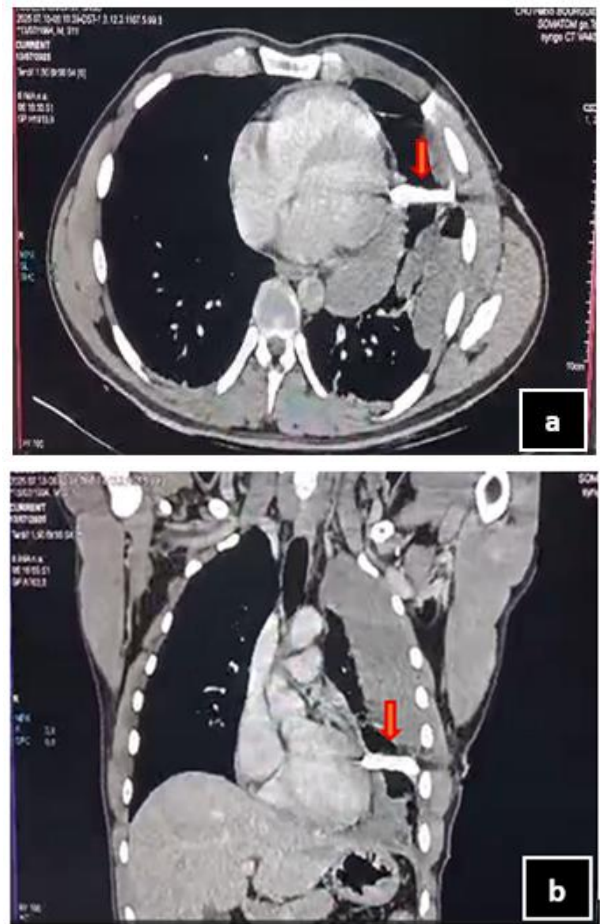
Transverse (a) and coronal (b) CT scans showing a 4 cm glass fragment lodged in the angula, in close contact with the right ventricle.
